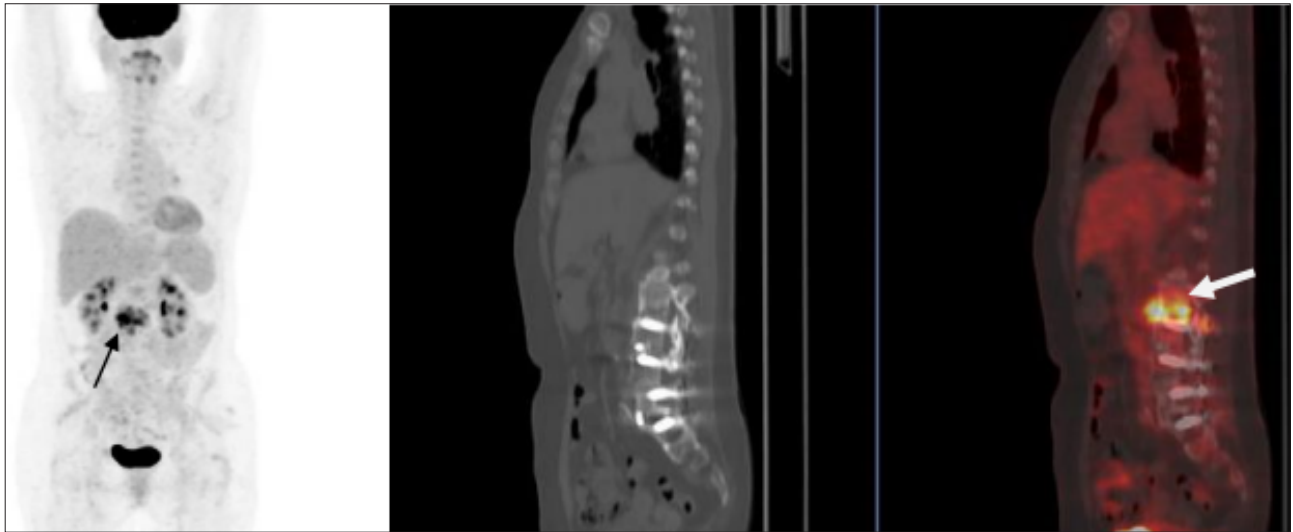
Full-body positron emission tomography scan reveals signs of discitis, with elevated 18-F-FDG uptake at L2/L3.
